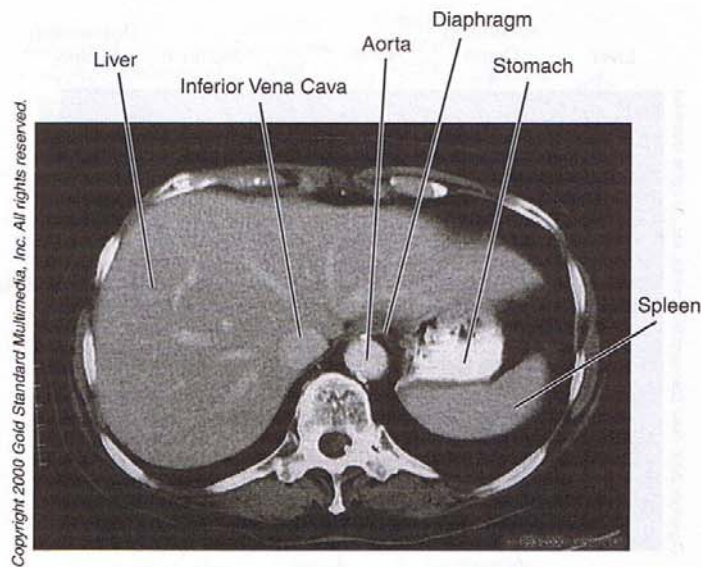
Abdomen: CT, T₁₁
